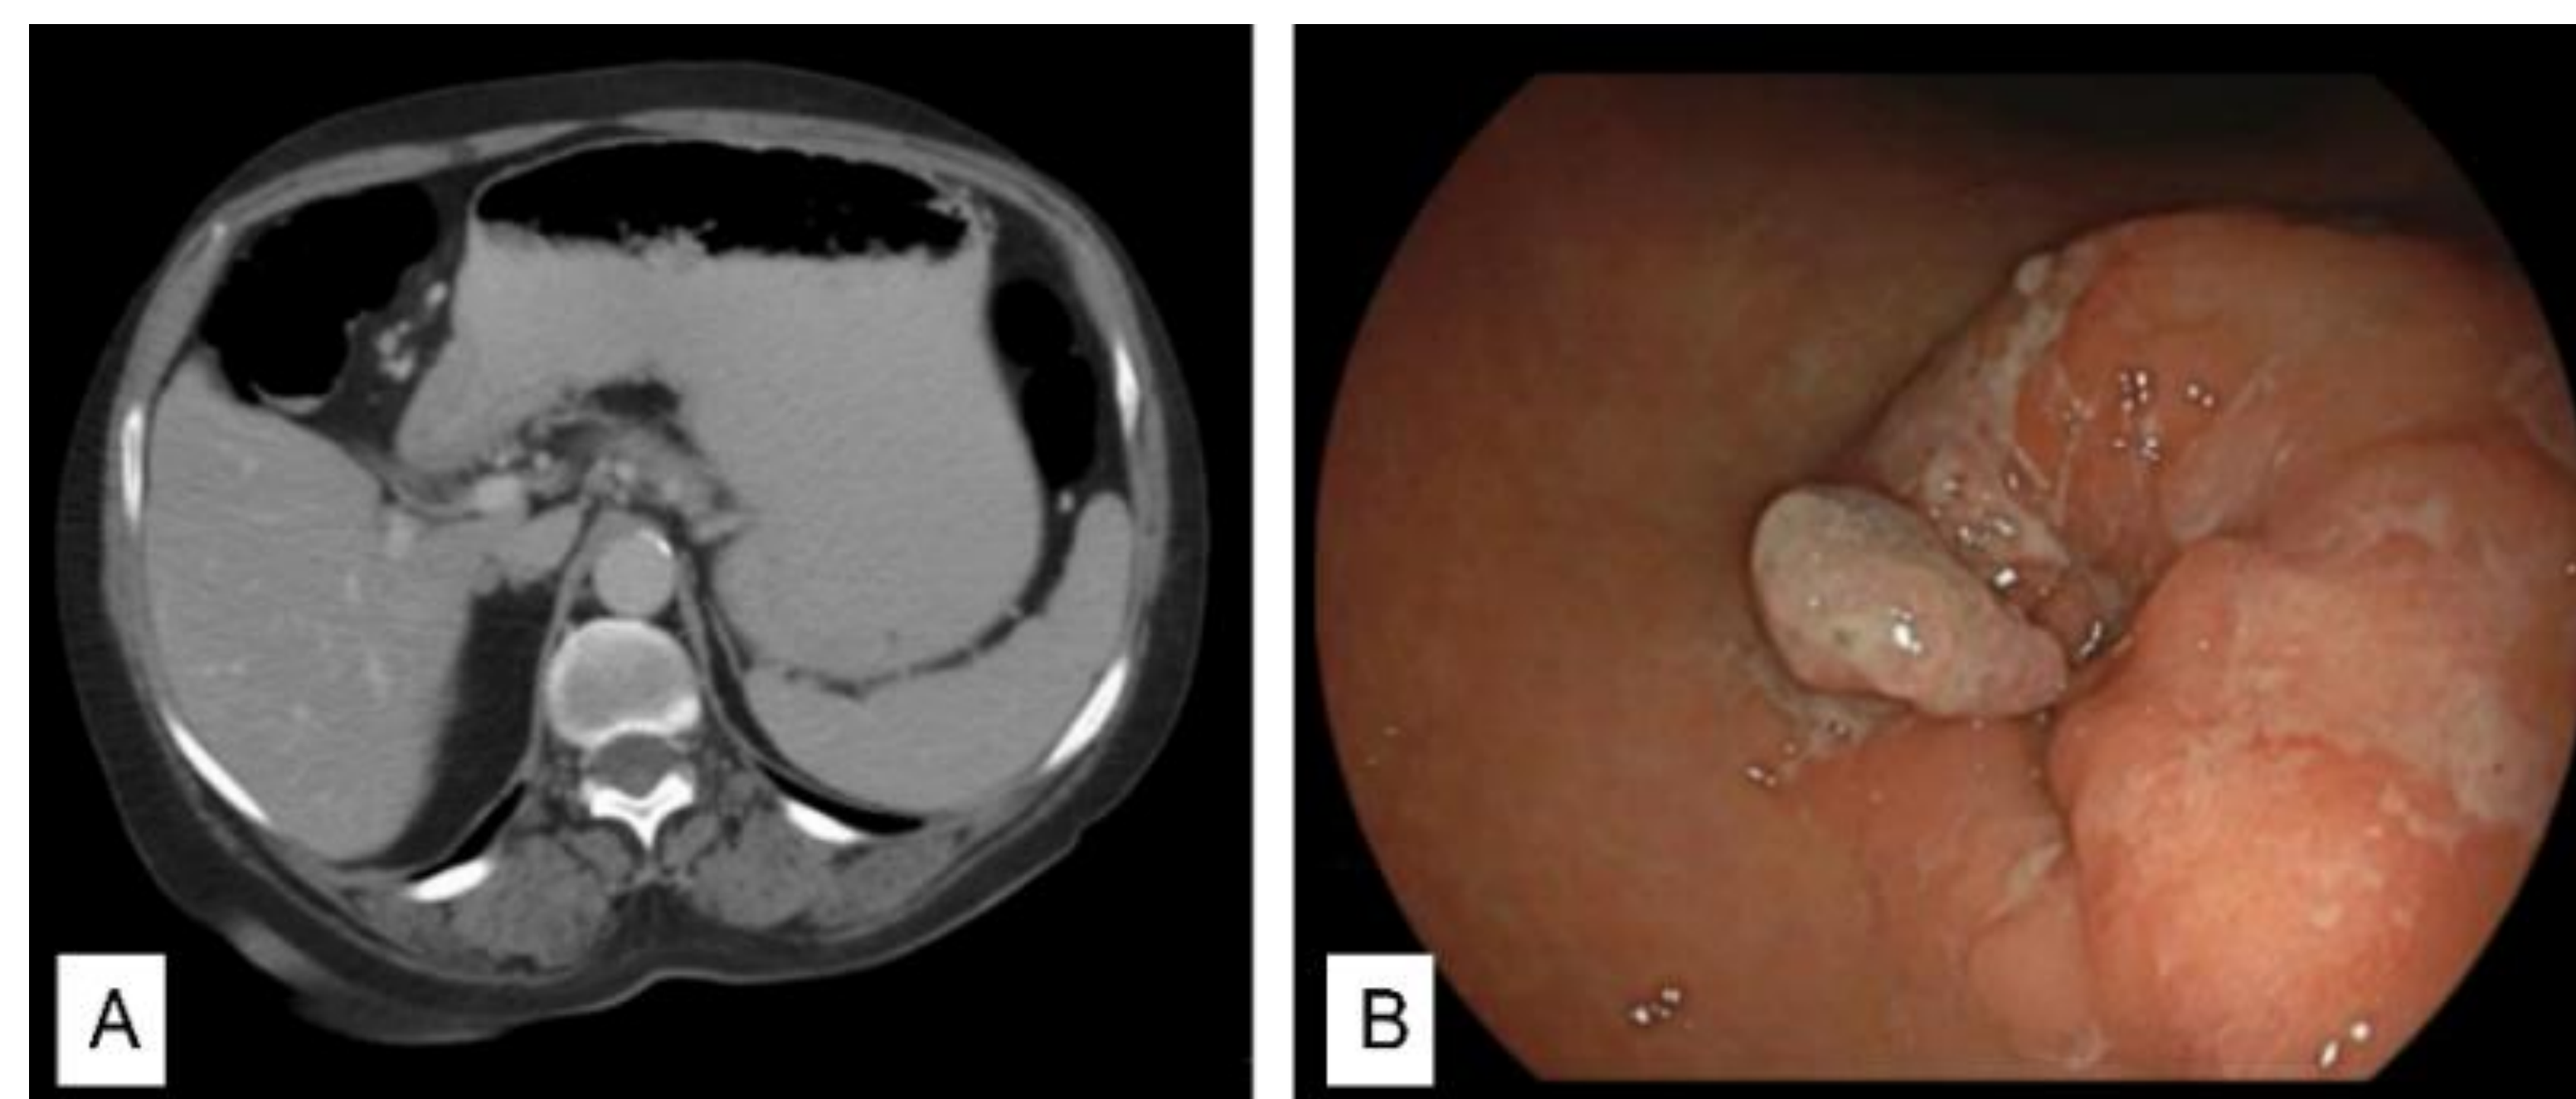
CT scan shows pyloric thickening and distention of the stomach (A). EGD shows circumferential area of erythema and edema in the pylorus that was difficult to pass with adult gastroscope (B).
